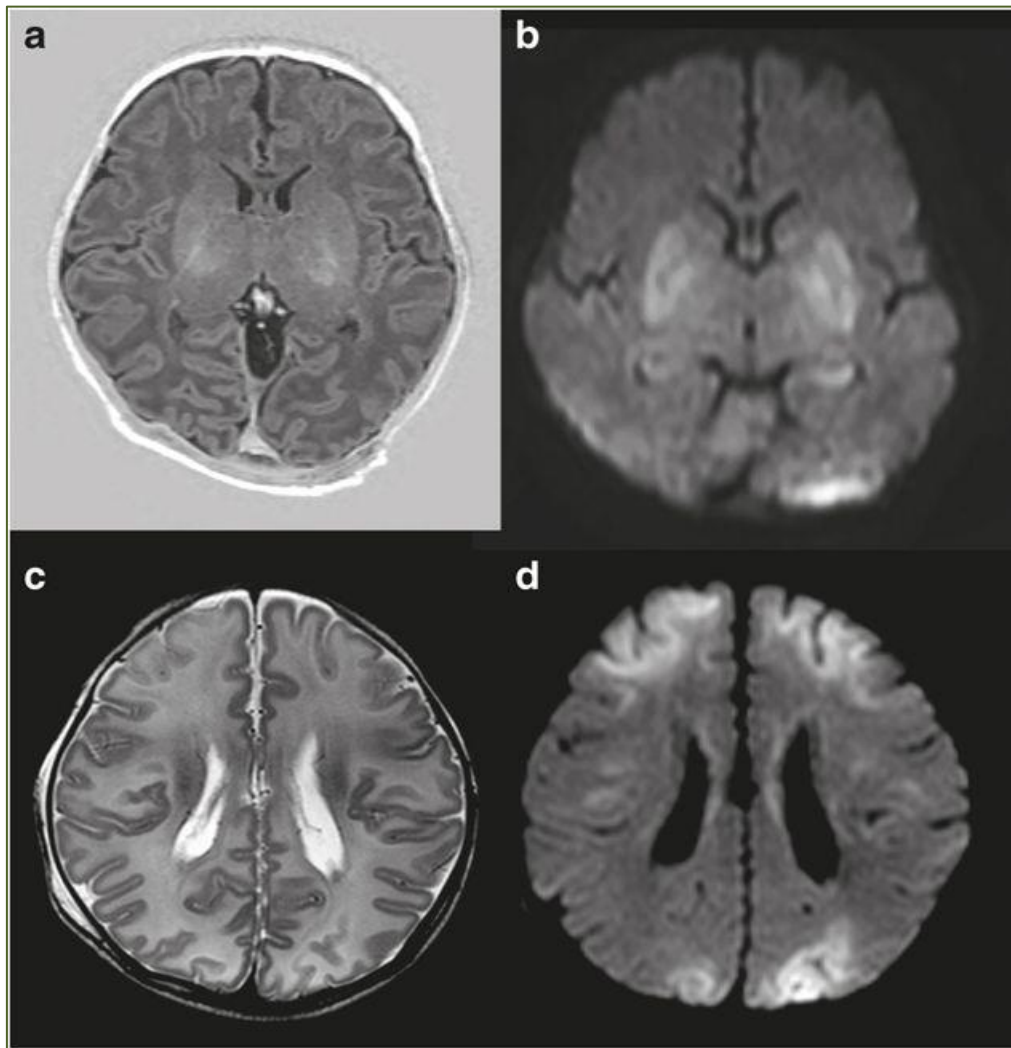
MRI finding in HIE (Robertson., 1990)
